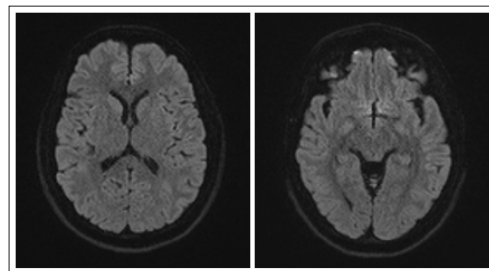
Axial Diffusion-Weighted MRI of the Patient's Brain
